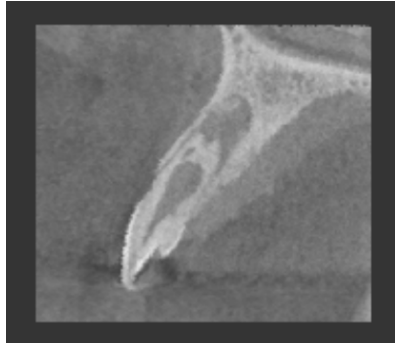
a. A CBCT image showing the immature root ,voids in the HTB and a PARL b. A 3D image of # 10, the void in the HTB is evident as well as the extension of the invagination into the tooth c. A 3D image of #10 video can be seen at <https://www.dentistry.iu.edu/index.php/departments/endodontics/research-case-reports/case-reports/>
